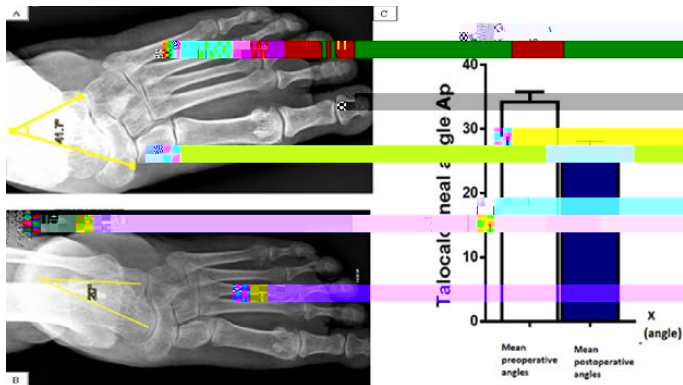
A) Preoperative Talocalcaneal Divergence Angle Measurement on an Anteroposterior Ankle Plain Radiograph. B) Postoperative Talocalcaneal Divergence Angle Measurement on an Anteroposterior Ankle Plain Radiograph. 325ce ier
